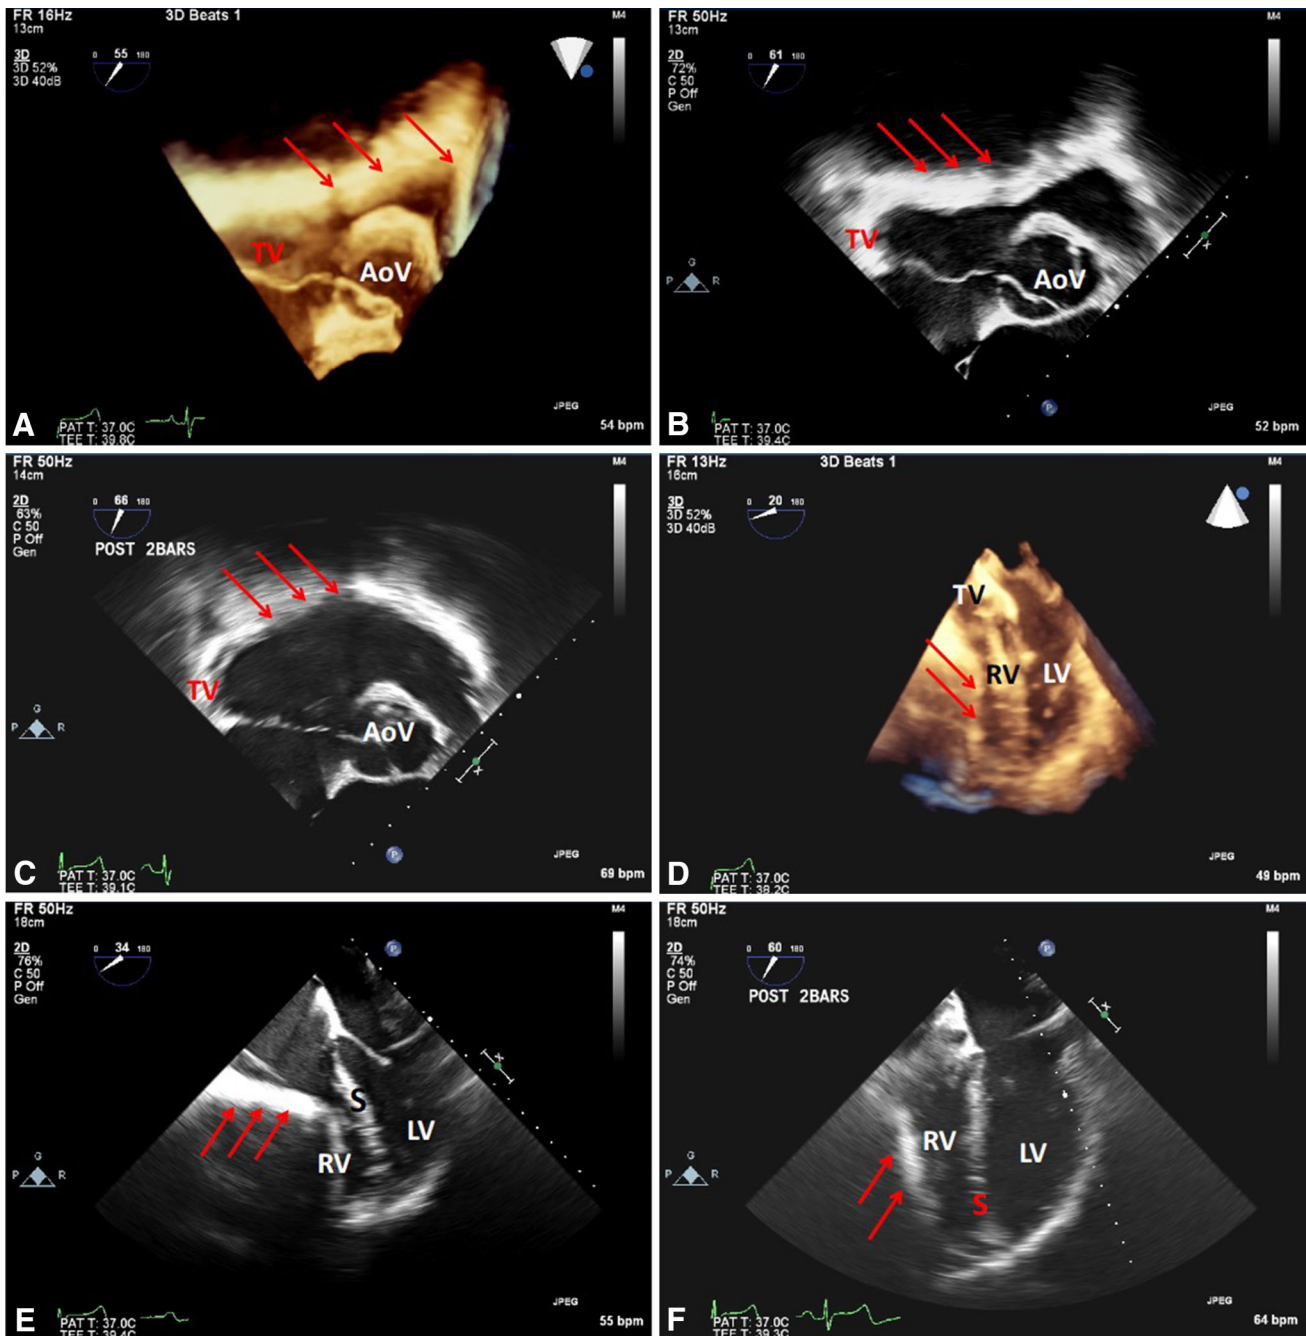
a Transesophageal echocardiogram (TEE) 3D short axis image at the level of the aortic valve (AoV). Arrows indicate right ventricle outflow tract (RVOT) compression. b 2D TEE image based short axis at the level of the AoV. Arrows indicate RVOT compression. c 2D TEE short axis image at the level of the AoV post repair shows relief of compression. d 3D TEE four chamber view
